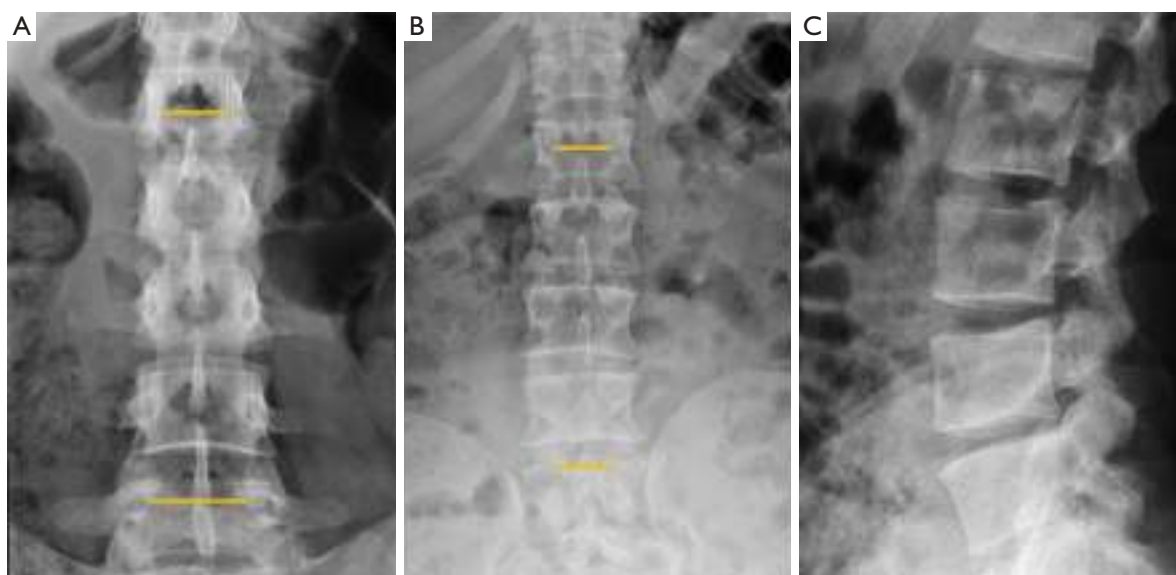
Lumbar spinal canal measurement. (A) Normal AP radiograph showing progressive widening of the interpedicular distance. In congenital stenotic canal; (B) this widening is not present; (C) lateral radiograph of congenital stenotic canal.
